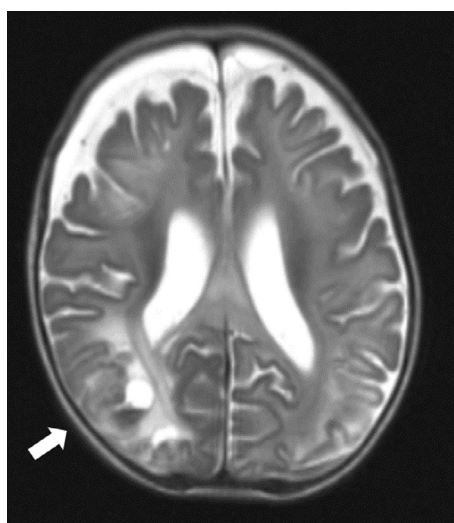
Parenchymal contusional cleft. Axial T2 sequence from a brain MRI examination of 4 months old (same patient as in Fig. 5C) demonstrates a right parieto-occipital cleft (arrow) in the gray white matter transition zone. The cleft contains hemorrhage forming a fluid/fluid level and is surrounded by edema.
